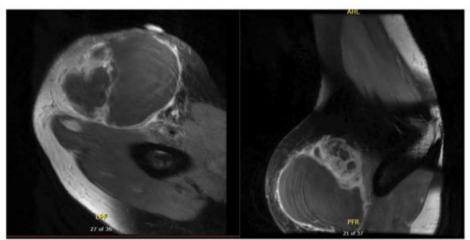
(left): initial axial post-contrast MRI of the right upper extremity; Figure 2b (right) is a sagittal view of the same scan.
